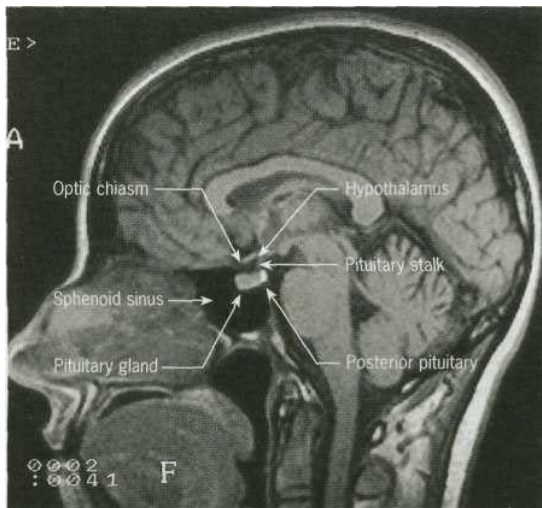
MR image of a sagittal section of the brain, showing the pituitary fossa and adjacent structures. (By kind permission of Dr Martin Jeffree.)
